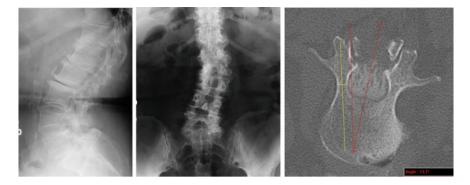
On the *left* and *middle panels*, bi-planar radiographs are shown. Radiographs are sometimes used in planning spine surgeries with complex patient morphology. On the *right*, an axial image from a CT scan is shown with distance and angle measurement lines superimposed
